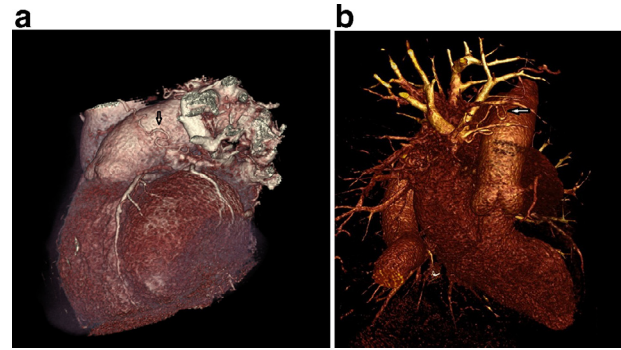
CT coronary angiogram in volumetric construction showing the left coronary artery fistula (white arrow).
